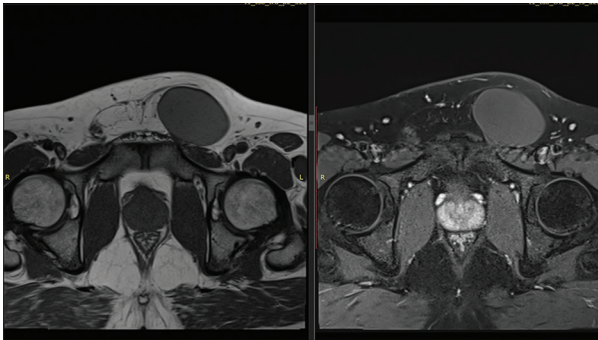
Post-contrast T1-weighted magnetic resonance imaging showing absence of internal enhancement within the lesion, suggesting a benign cystic nature
